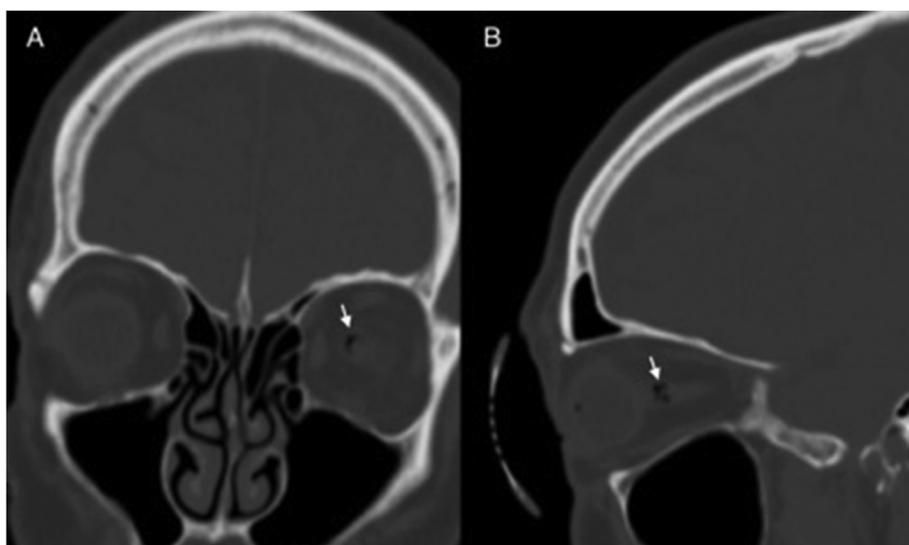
CT scan of the orbits showing an air bubble (white arrow) in the left optic nerve sheath on both coronal (Fig. 1A) and sagittal (Fig. 1B) cuts.
